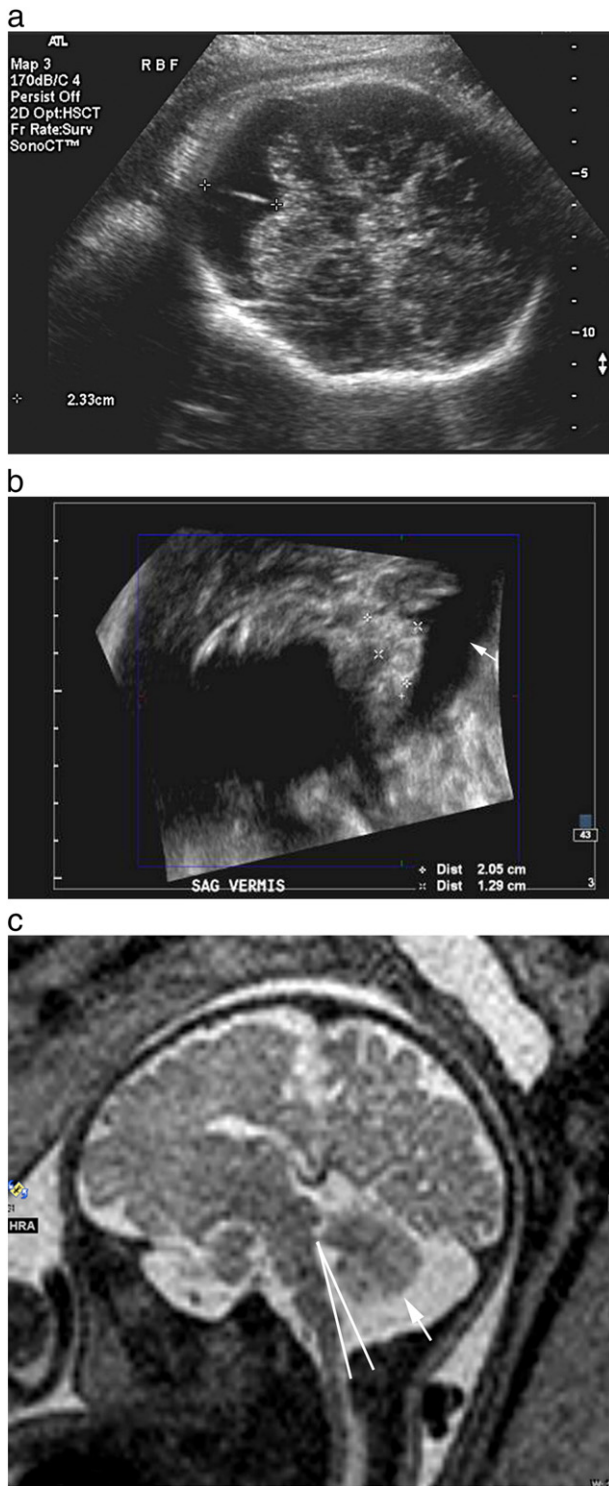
Mega cisterna magna incidentally detected on prenatal ultrasound. (a) Axial sonographic image from a 36-week prenatal ultrasound demonstrates enlargement of the cisterna magna (2.3 cm marked by calipers) with normal cerebellar contours. Sagittal reformat (b) from a three-dimensional US shows a fully formed vermis and large cisterna (arrow). (c) Midline sagittal T2-weighted image from a prenatal MR at 38-weeks gestational age confirms enlargement of the cisterna magna with normally formed cerebellum and normal tegmento-vermian angle (angle measurement shown in c). Postnatal images confirmed mega cisterna magna in this fetus (not shown here).
